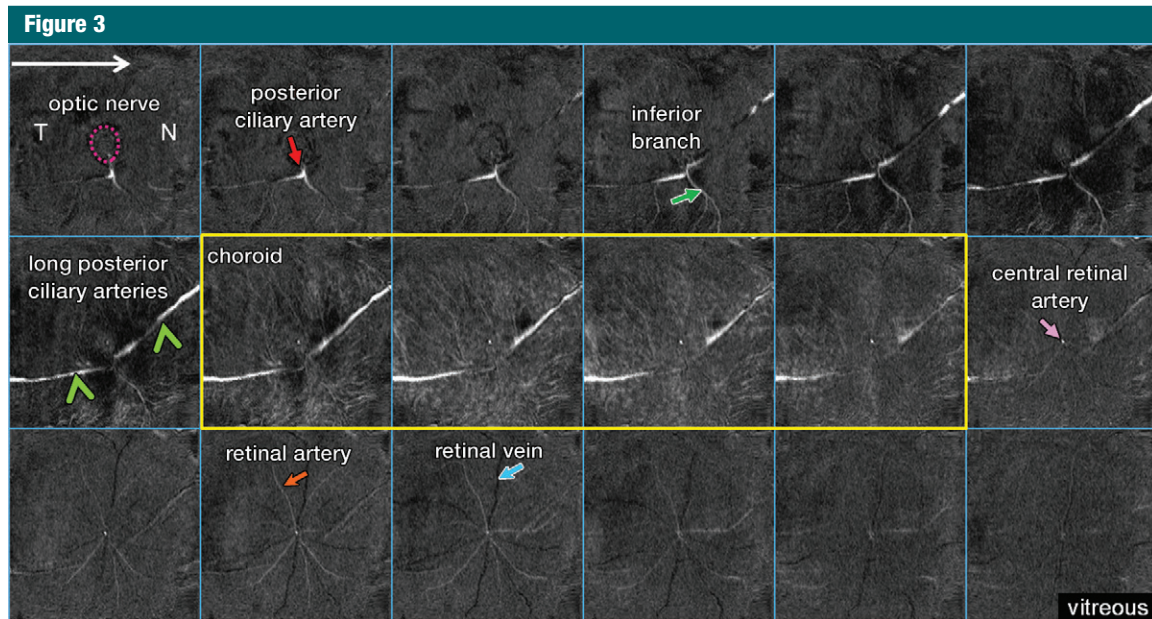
Flattened anatomy of the posterior eye. From left to right and top to bottom, MR images (40/4.3) show sections from posterior at the top left (optic nerve) to anterior at the bottom right (vitreous). The inferior branch (green arrow) refers to the inferior branch of the posterior ciliary artery. *N* = nasal side, *T* = temporal side, purple dotted circle = optic nerve, yellow outline = choroidal vascular layer.
